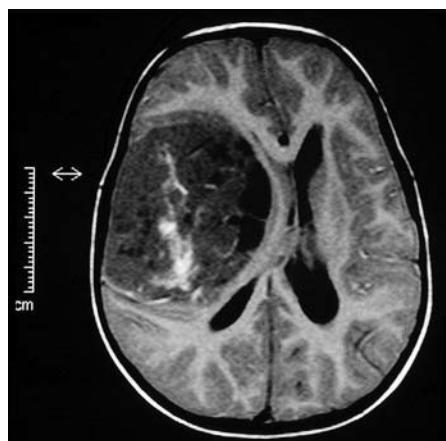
MRI of an ependymoblastoma bordering the lateral ventricle.
